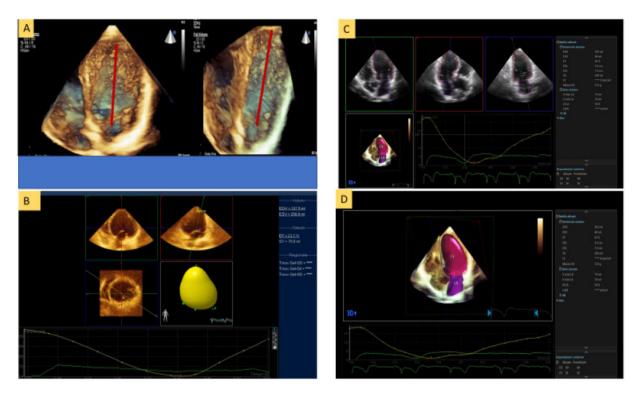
(A and B) Left ventricular ejection fraction measurement with three-dimensional transthoracic echocardiography. (C and D) Measurement of left ventricular ejection fraction, stroke volume, and left atrial volume changes using an automated speckle tracking method.
